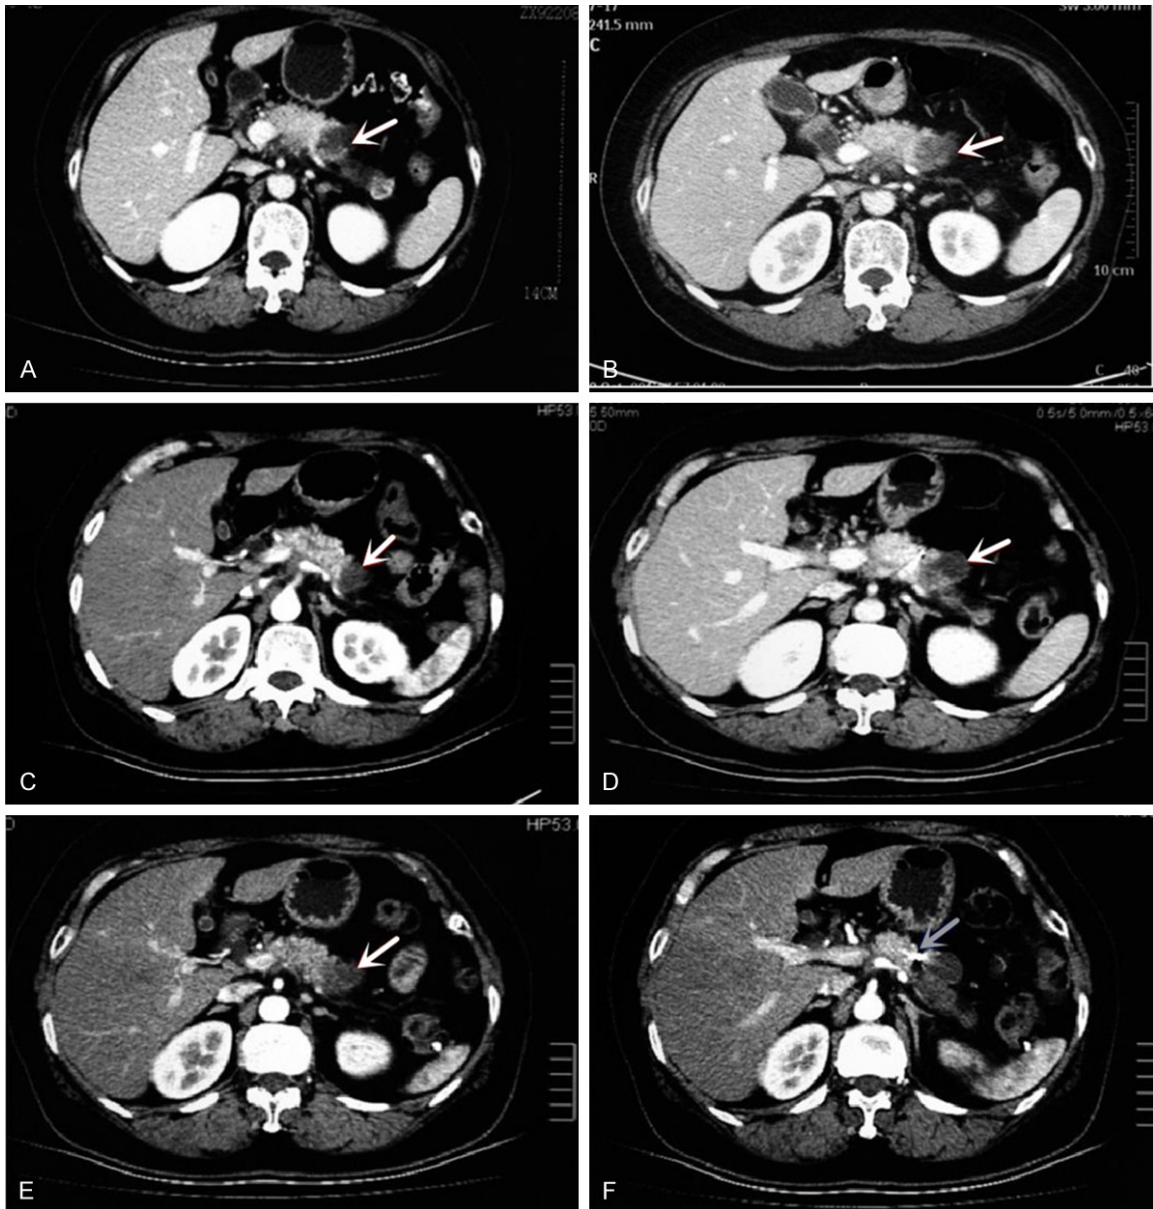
Computed tomography (CT) scan of case 3 with LAPC prior to and following the twice SBRT. A. CT scan prior to the first-course treatment shows a mass in the pancreatic body (white arrow). B, C. CT scan 3 months and 6 months following the first SBRT course (white arrow). D. CT scan prior to the second-course treatment shows the local recurrence of the tumor in the pancreatic body (white arrow). E. CT scan 2 months following the second SBRT course (white arrow). F. Fiducial showed in this picture (gray arrow).
